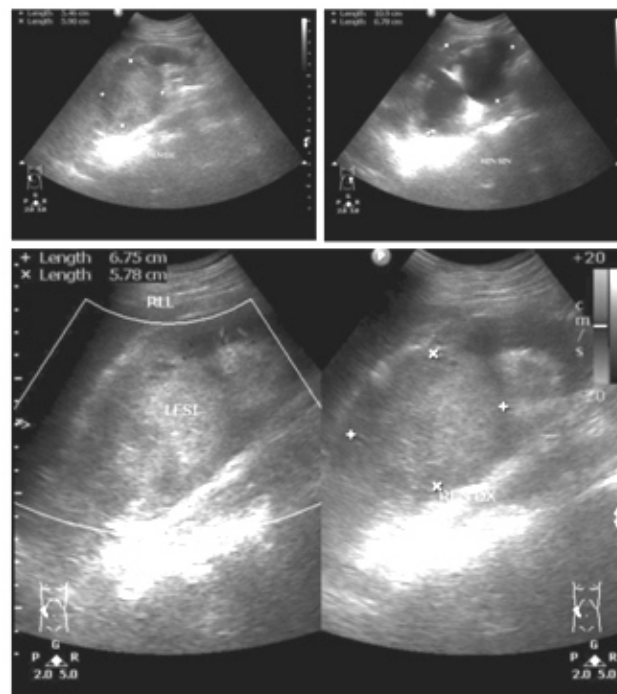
Ultrasonography in September 2021 showing left renal pelvis mass.
